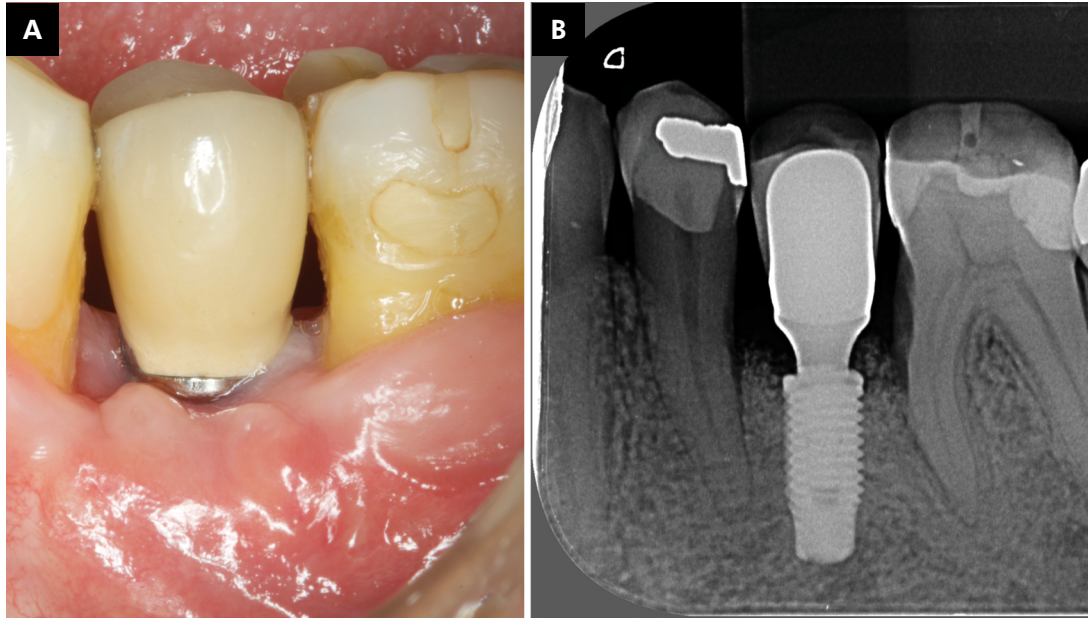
A) Clinical aspect after healing. B)X-ray after healing.
